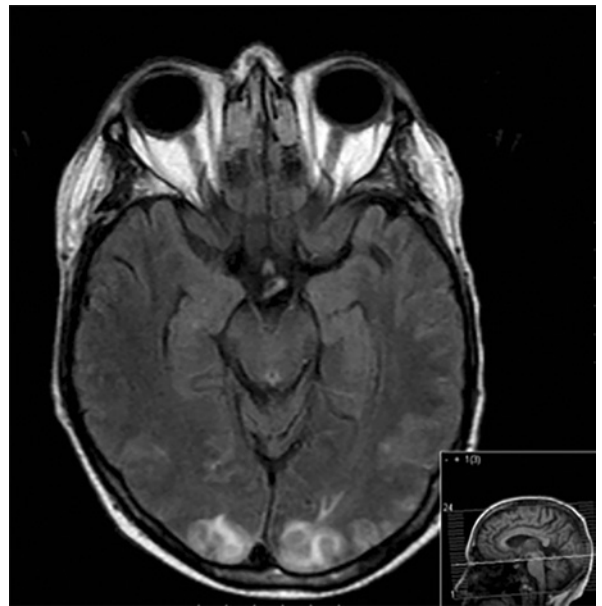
Magnetic resonance imaging scan of the brain (T2 with flair) shows high signal bilaterally involving the occipital lobes in keeping with posterior reversible encephalopathy syndrome.
